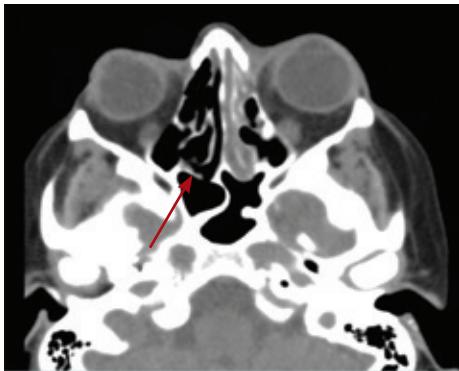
CT demonstrates stable partial opacification of left ethmoid air cells and mucosal thickening in left maxillary sinus related to ostiomeatal dysfunction (red arrow).
